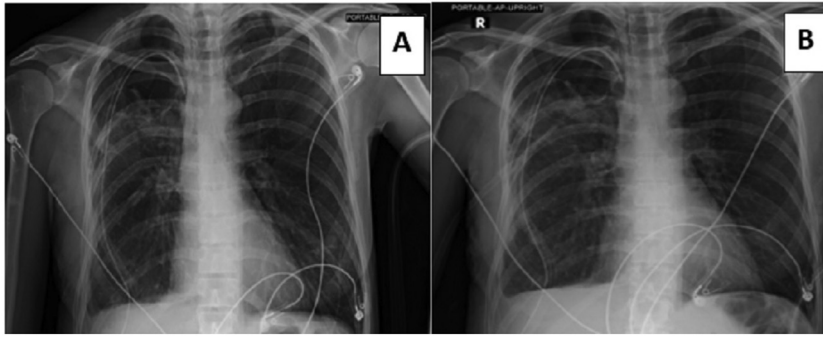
Chest X-ray obtained 24 (A) and 48-hours (B) without suction showed persistent small apical pneumothorax.
